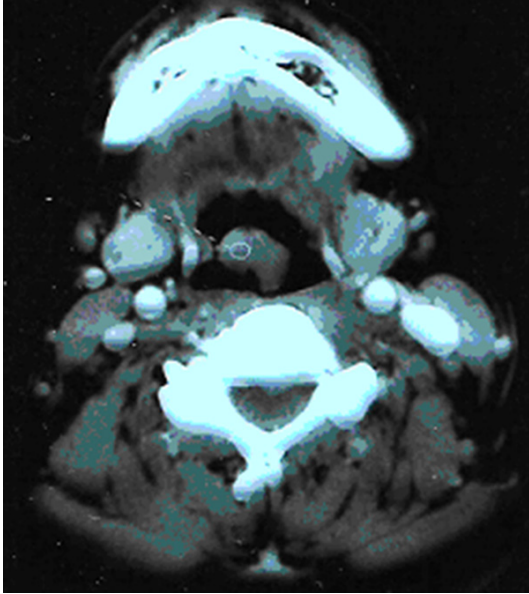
CT scan of the larynx with a mass on epiglottis.
